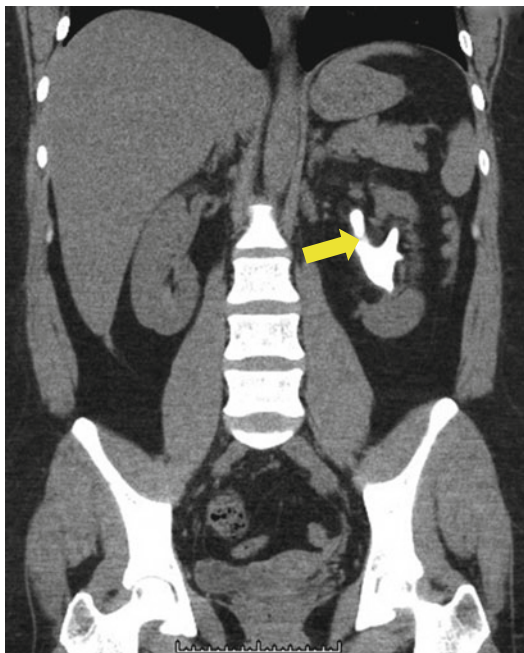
Coronal CT scan image of a left renal staghorn calculus (yellow arrow)
